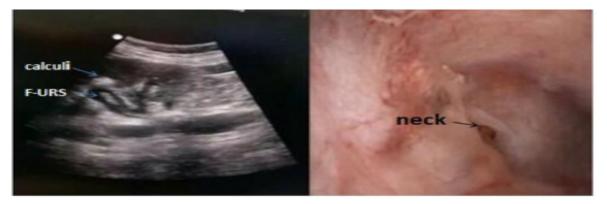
Look for the diverticular neck guided by ultrasound.
